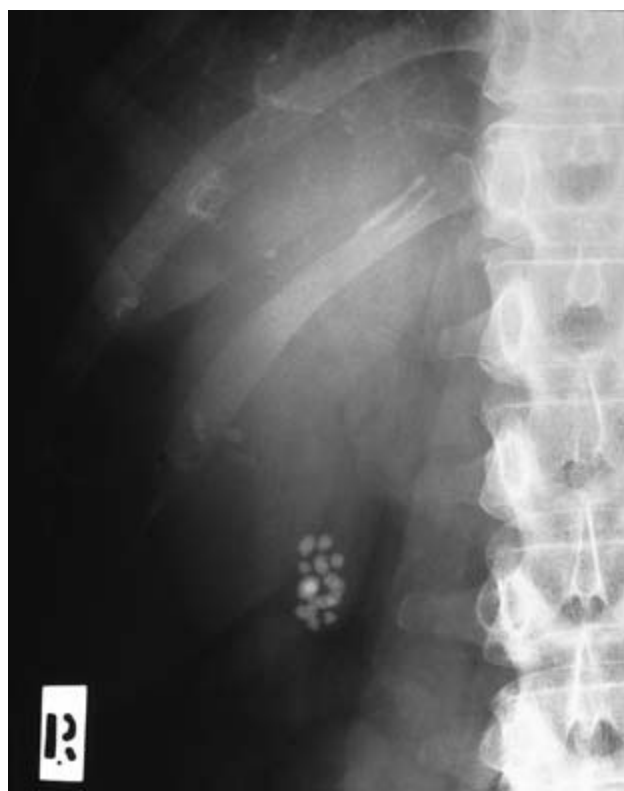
Plain abdominal X-ray showing radio-opaque gallstones. Oral bile acid therapy is contraindicated.
